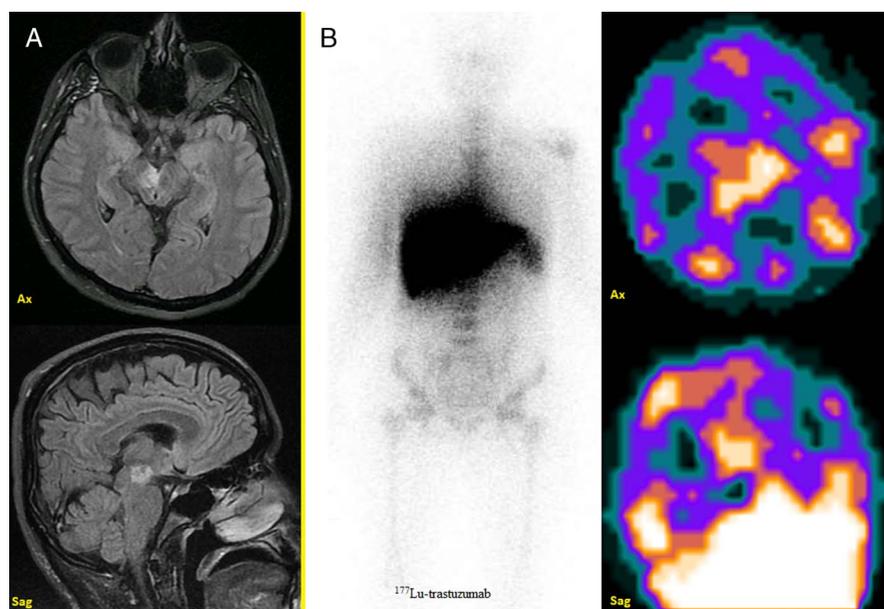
A 49-year-old woman with HER2-positive breast cancer and brain metastasis in the brain stem observed on MRI (A). She underwent 1 cycle of ^{177}Lu -trastuzumab (Herceptin) (1.85 GBq) that showed intensive radiotracer uptake in the lesion according to the posttherapy scintigraphy (B).
